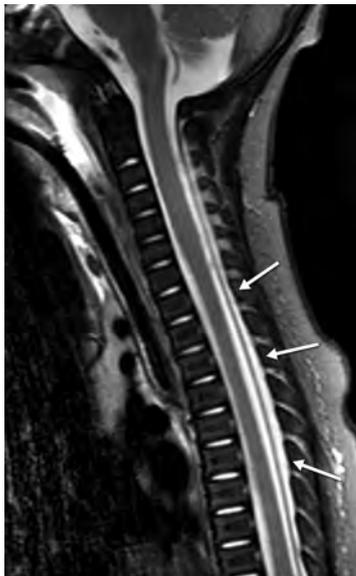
Four-month-old patient. Sagittal midline T2WI shows abnormal posterior extradural fluid within the cervical and thoracic region (arrows). The fluid was isointense to CSF on T1-weighted images. Interspinous ligamentous injury is present (not shown).
